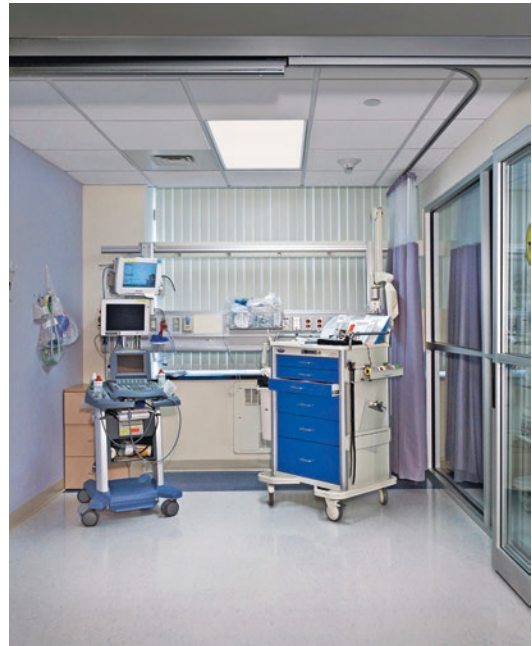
Photo of a block area. At our hospital, epidural and peripheral nerve blockade are frequently performed in the PACU. The block area is a dedicated patient location that includes full monitoring, the regional block ultrasound unit, stimulating catheters, and a fully stocked regional anesthesia cart. It is immediately adjacent to the operating room and allows rapid turnover with minimal distraction
